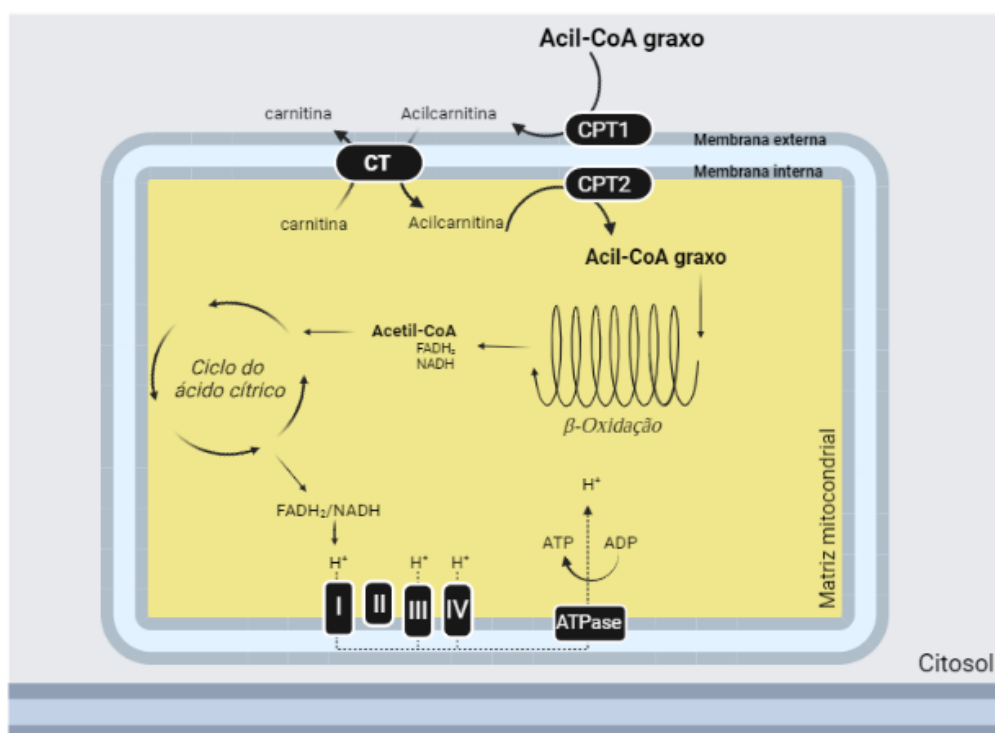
Transporte e oxidação do ácido graxo na mitocôndria. Para acessar a matriz mitocondrial, o Acil-CoA graxo precisa ser convertido em Acilcarnitina pela CPT1 β , e então translocado do citosol pela CT. Em seguida é reconvertido em Acil-CoA graxo pela CPT2 e entra na β -Oxidação. O Acetil-CoA gerado passa pelo Ciclo de Krebs e libera FADH e NADH para a CTE. CT: carnitina transferase; CPT1 e CPT2: carnitina palmitoiltransferase do tipo 1 e 2, respectivamente; NADH: dinucleotídeo de nicotinamida e adenina; FADH: dinucleotídeo de flavina e adenina; ADP: adenosina difosfato; ATP: adenosina trifosfato; CTE: cadeia de transporte de elétrons; I, II, III e IV: complexos I, II, III e IV da CTE. Adaptado de Stanley, (2010) [49].
